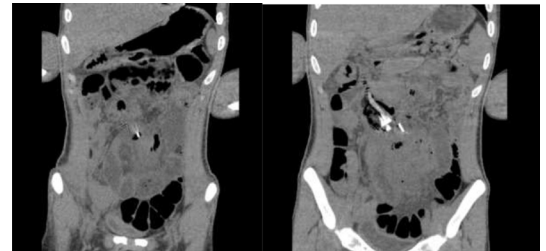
CT of the abdomen demonstrating multiple foreign bodies in the duodenum and proximal small bowel, with evidence of perforation.
